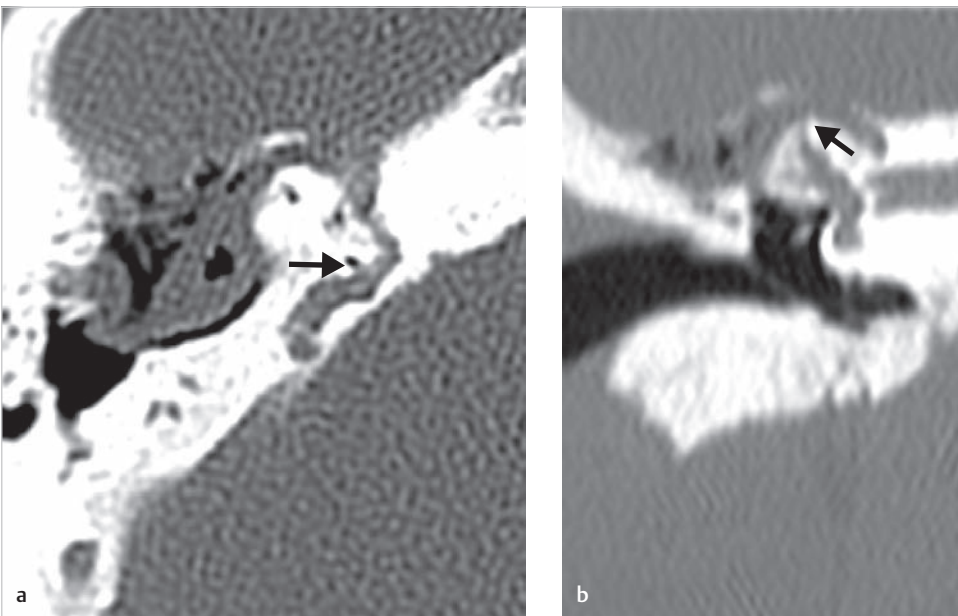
Both the axial (a) and the coronal (b) CT demonstrated extension of cholesteatoma medially to the superior semicircular canal. A labyrinthine fistula is identified in the canal (*black arrows*). Extensive erosion of the tegmen is seen in the coronal section.
